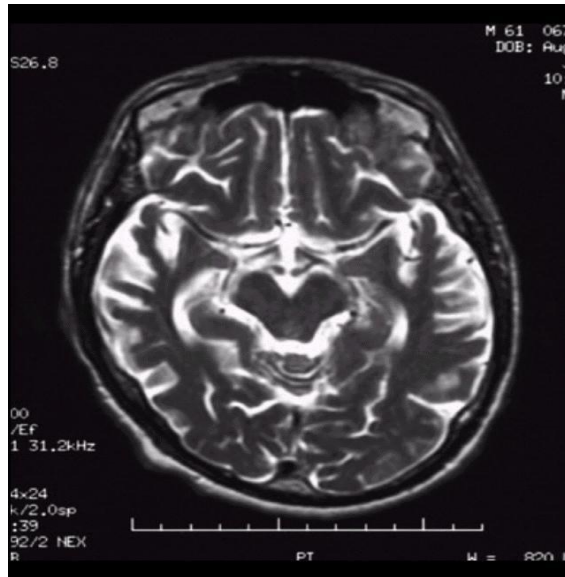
Axial, T2-weighted magnetic resonance imaging (MRI) scan of the brain reveals atrophic changes in the temporal lobes.
